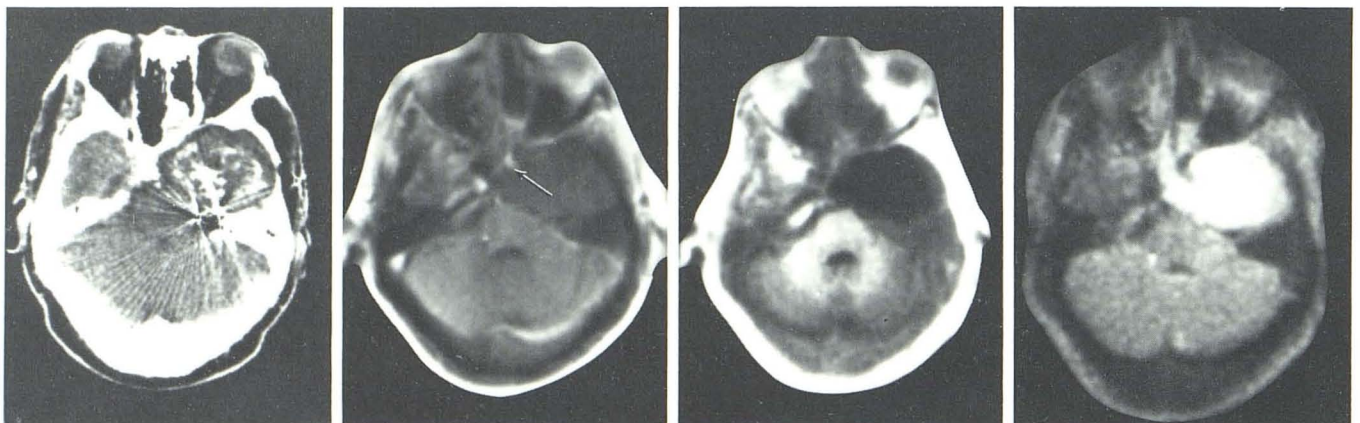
Epidermoid tumor after incomplete resection. A, Contrast enhanced CT. B, SR₃₀₀. C, IR_{1400/400}. D, SE_{1080/40}. CT scan (A) shows partially calcified tumor together with artifact from metal clip. Displacement of right internal carotid seen in B (arrow). Tumor defined in C and D.
